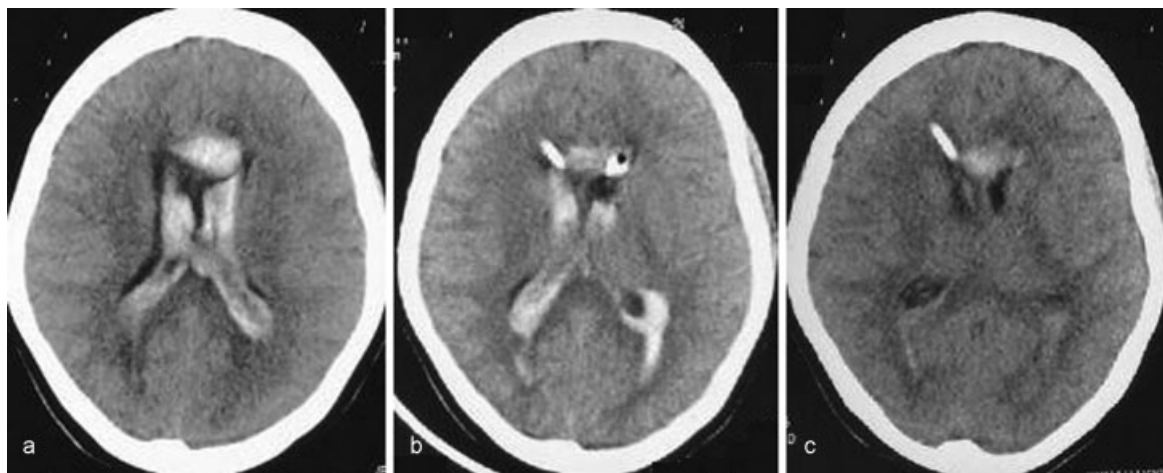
Computed tomography (CT) scans show a pronounced reduction in intraventricular hemorrhage volume on postoperative day (POD) 5. (a) Preoperative CT. (b) First postoperative CT. (c) CT on POD 5.
